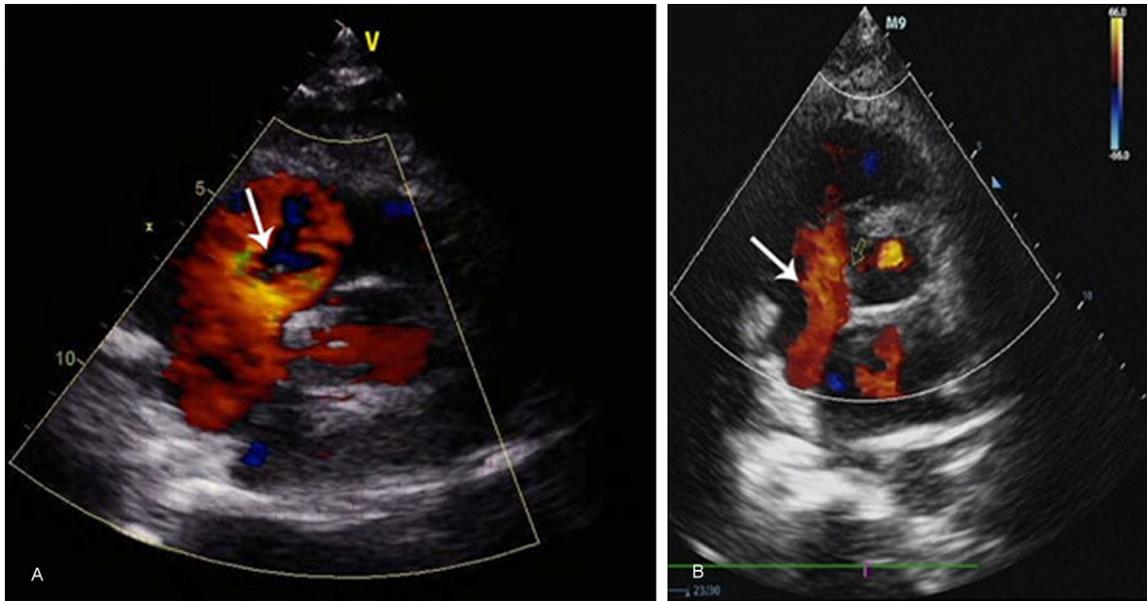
Transthoracic echocardiography at one week (A) and one month (B) after surgery: absence of residual shunt in the repair site (arrows).
